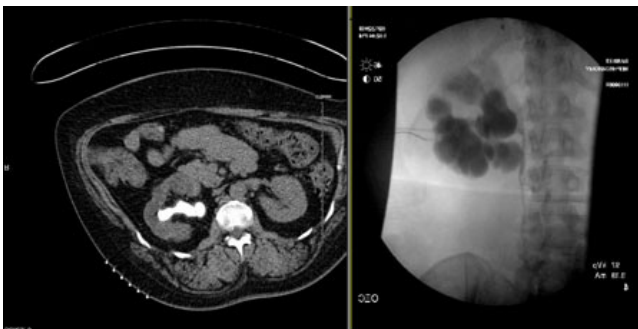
CT during initial stone presentation and IR nephrostomy.
